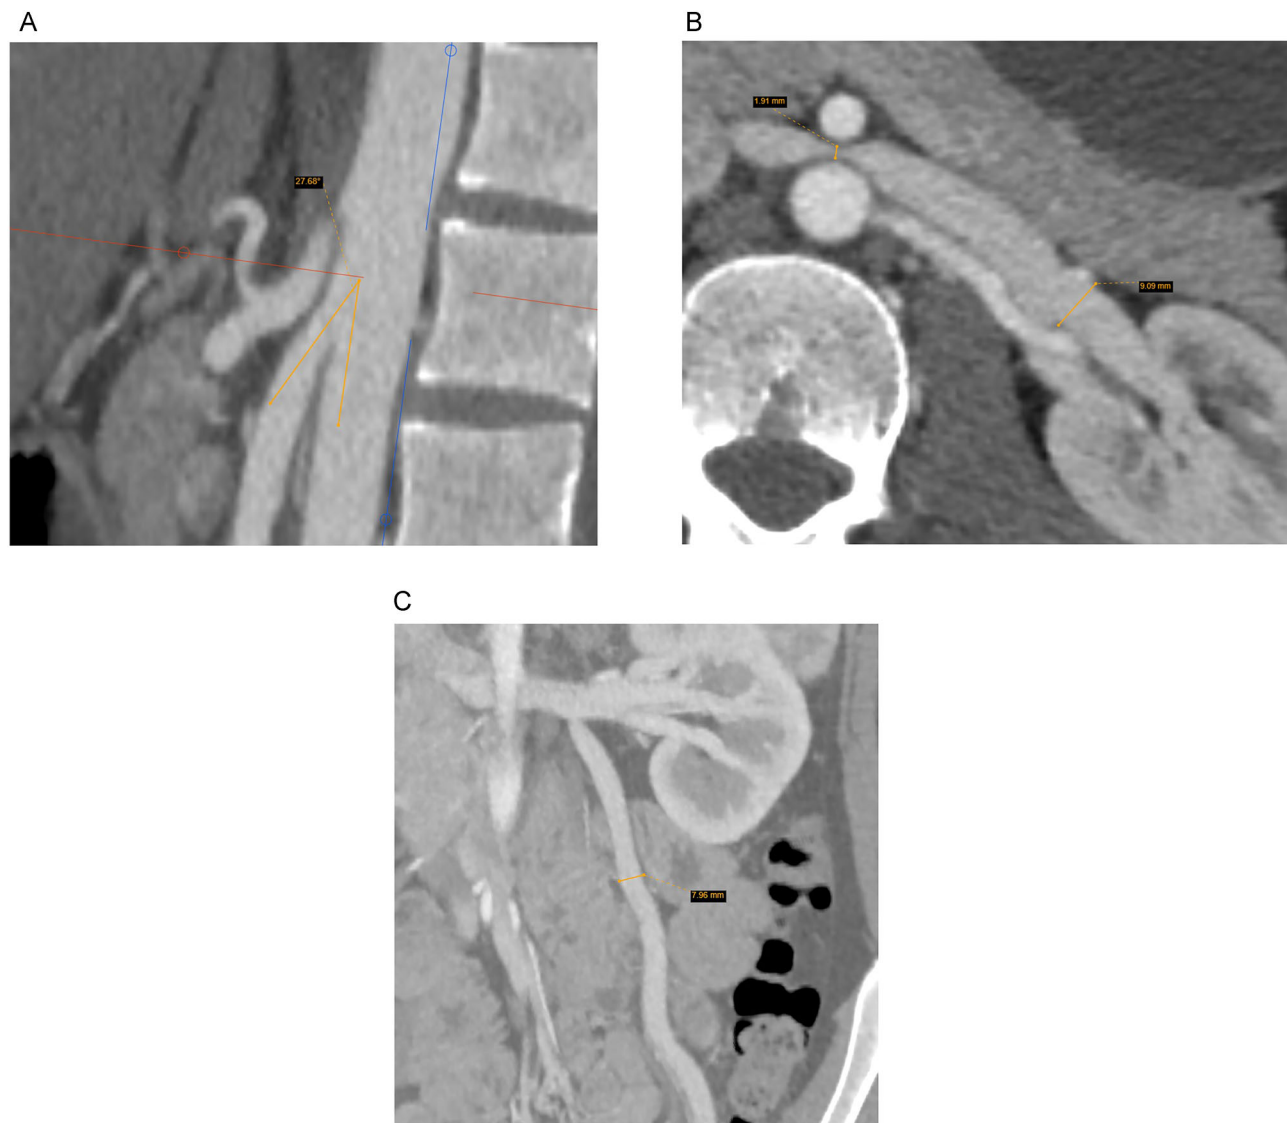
Computed tomography images of the nutcracker phenomenon. (A) The angle (yellow lines) between the aorta and superior mesenteric artery. (B) Left renal vein compression between the aorta and superior mesenteric artery (short yellow line): the diameter of LRV is 1,91 mm at the site of compression and 9,09 mm at the pre-compression area. (C) Left gonadal vein dilatation and reflux (yellow line).
